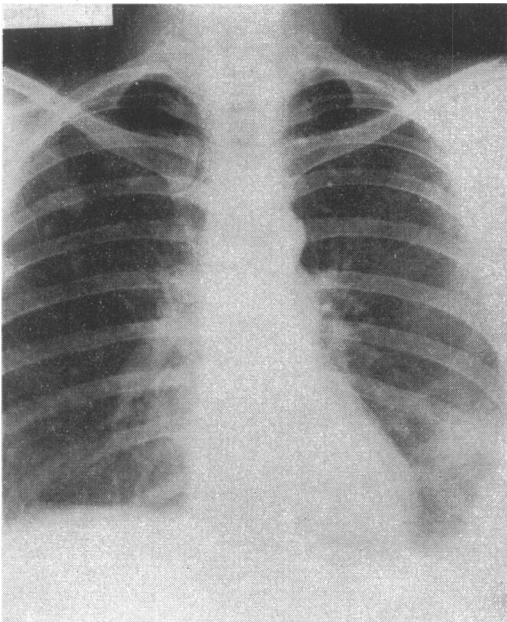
Case 1 *Radiograph of chest, August 1962, showing residual pleural thickening on the left side, and persistent nodules*
